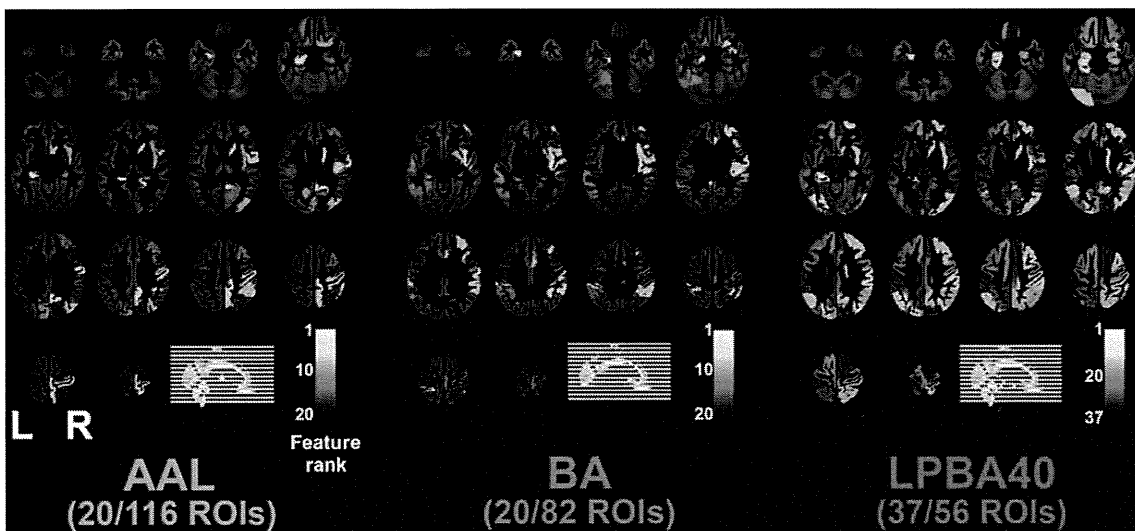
Selected region maps from the SVM-RFE procedure, which revealed the highest performance, overlaid to representative structural MR images. The regions with the highest rank are colored in white and those with the lowest rank are colored in black. AAL, Automated Anatomical Labeling; BA, Brodmann's areas; LPBA40, LONI Probabilistic Brain Atlas.
